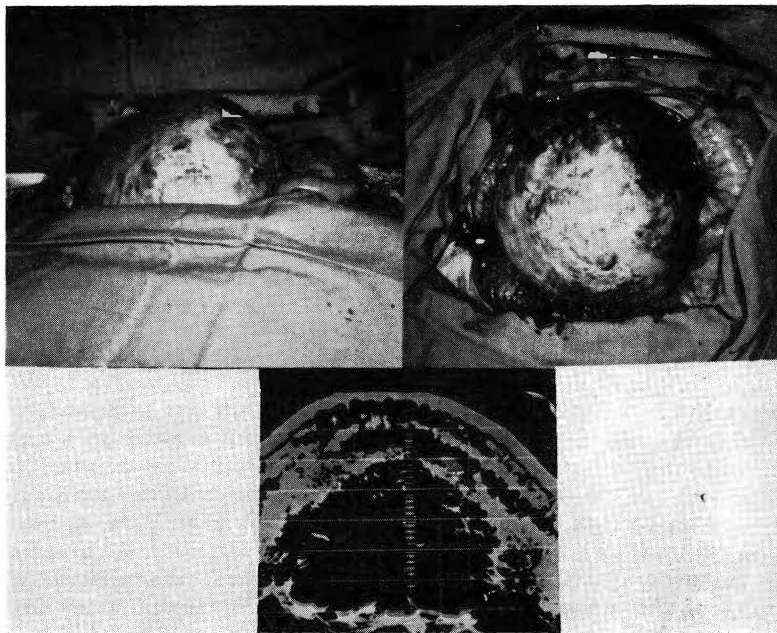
Sonogram on the bottom shows a clear black area surrounded by dense echo pattern characteristic of a pseudomucinous ovarian cyst. The appearance of the tumor at surgery is shown in the upper two pictures. Reprinted from *Am. J. Obstet. Gynec.* 90: 655, 1964. (C. V. Mosby)
